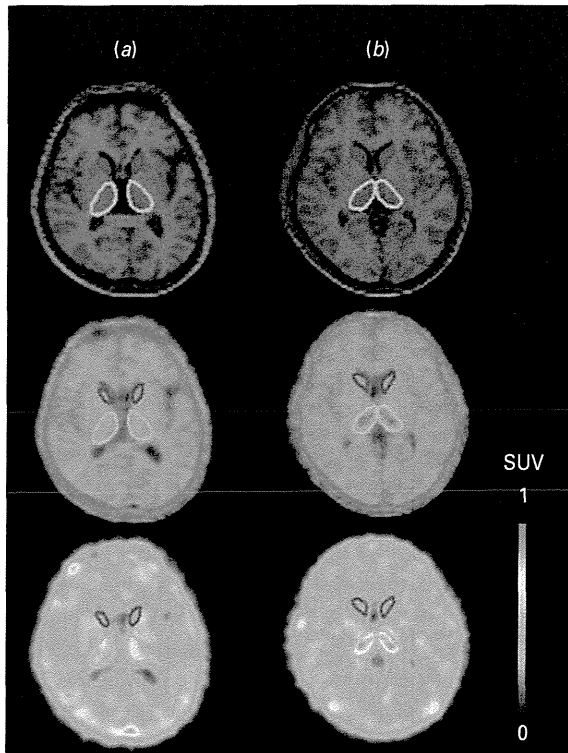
Magnetic resonance imaging (MRI) and positron emission tomography (PET) images of a patient taking 150 mg/d of nortriptyline (a), and a normal subject not taking any drugs (b). The upper row shows MRI images, the middle row shows fused images of both the MRI and PET summated image, and the lower row shows PET summated images of the subjects. Examples of volumes of interest for the caudate nucleus and thalamus are also displayed. The color bar indicates standard uptake value (SUV).
